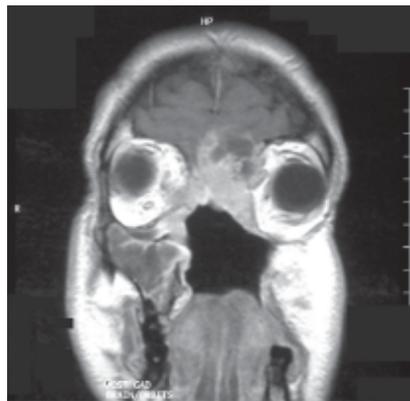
Coronal MRI showing tumour replacing the ethmoids, invading orbital fat and displacing the left globe inferolaterally.
